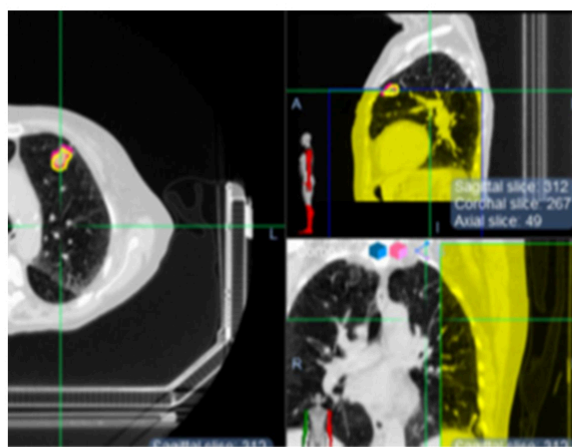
GTVo (in pink color) defined at the first phase is locally DIR to the nodule in another phase of 4D CT. Three orthogonal cutting through the lung (green lines) allow us to measure dimensions of the Lung at the GTV level. GTV relative locations to the stable Apex, mediastinum and posterior chest wall (CW) are measured and recorded
